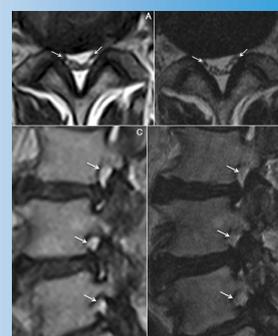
(A, B) Corresponding Axial T2-Weighted MRI images at 0.25T (A) and 3.0T (B) showing descending nerve roots (arrows). (C, D) Corresponding Sagittal T2-Weighted MRI images at 0.25T (C) and 3.0T (D) showing exiting roots (arrows).
